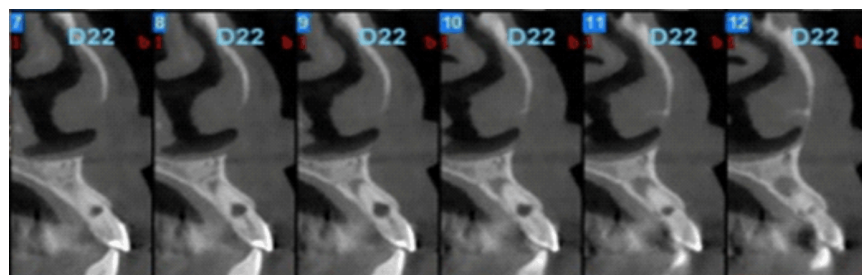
Preoperative CBCT. Sagittal view of neighboring slices showing location and size of internal resorptive defect without root perforation and the associated chronic apical periodontitis in tooth 22.
